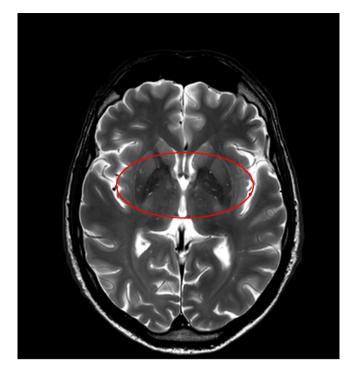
Cerebral Magnetic Resonance Imaging sequence Turbo Spin Eco Sense which shows minute focal points of altered signal in the white matter of the semi-oval centers (red area).
